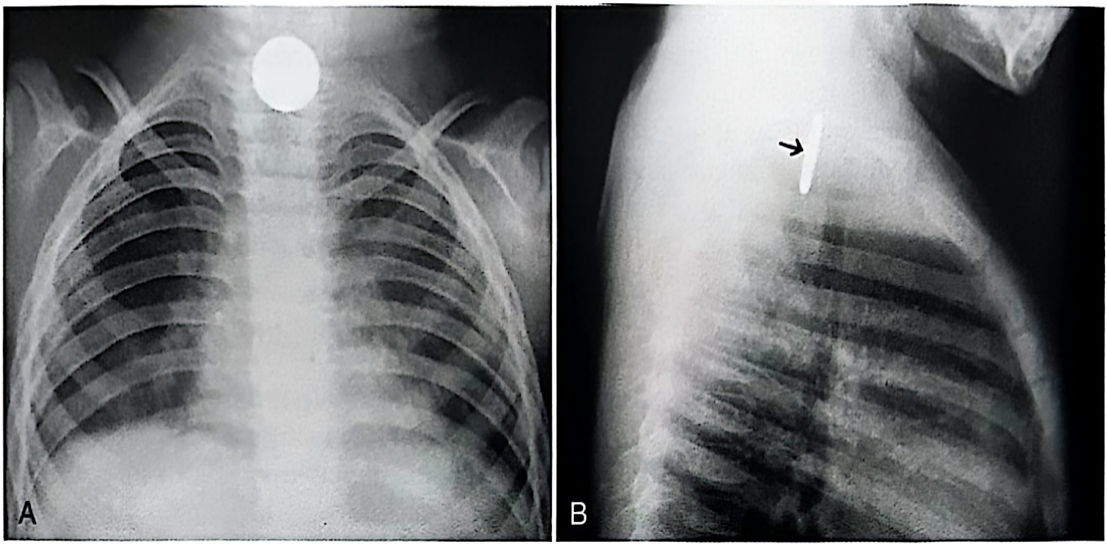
Chest radiographs demonstrate foreign body (coin) in child's lower cervical esophagus. (A) Frontal projection. (B) Lateral projection.
